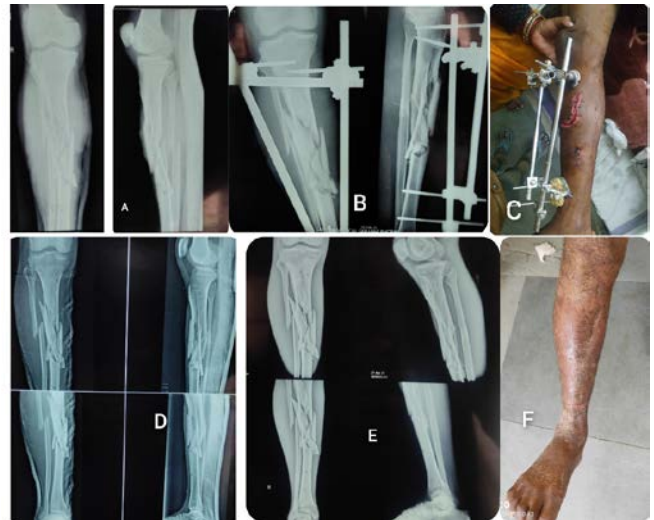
A 45-year-old man presented with compound grade IIIa, anteroposterior radiograph showing comminuted fracture both bone right leg (a), which was treated by External Fixation [B] with compound wound [c]; Follow up after 6 months with complete wound healing (D). 7 months later, radiological union.[E,F]
